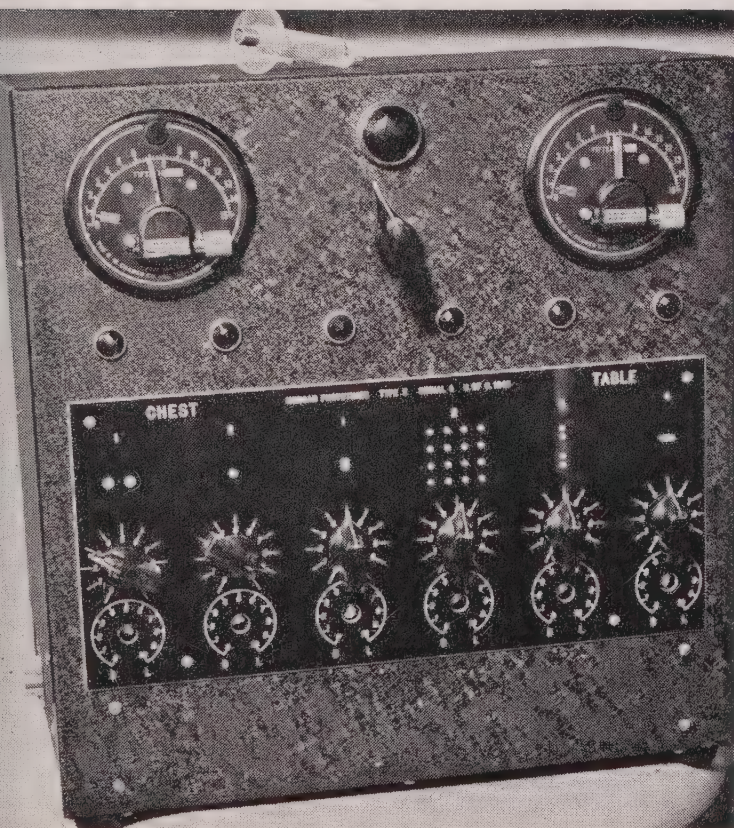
Phototimer for general radiography as supplied to the Army and Navy.
